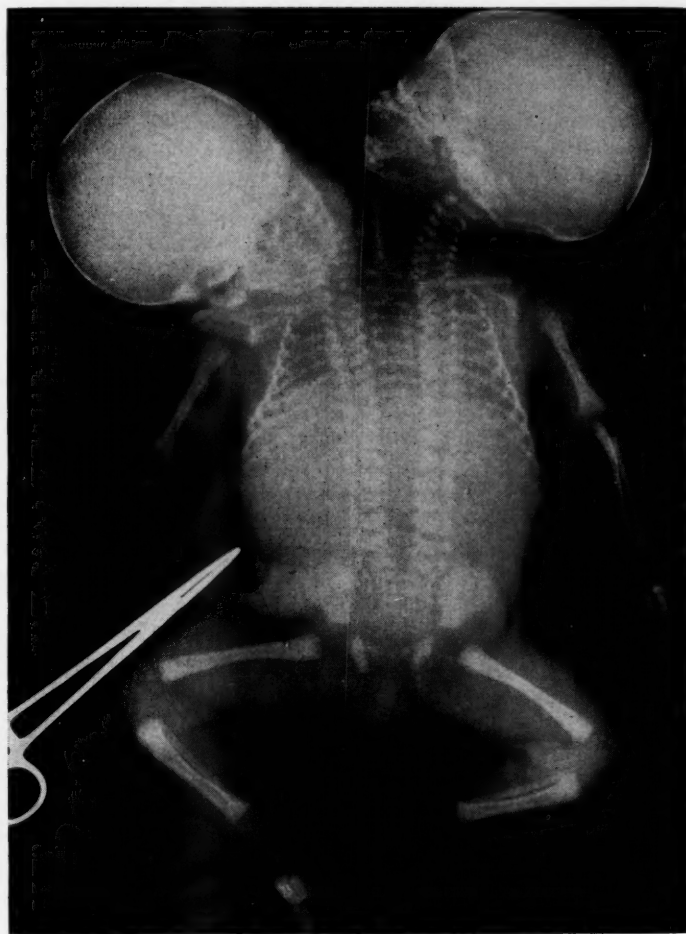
Postmortem roentgenogram.
